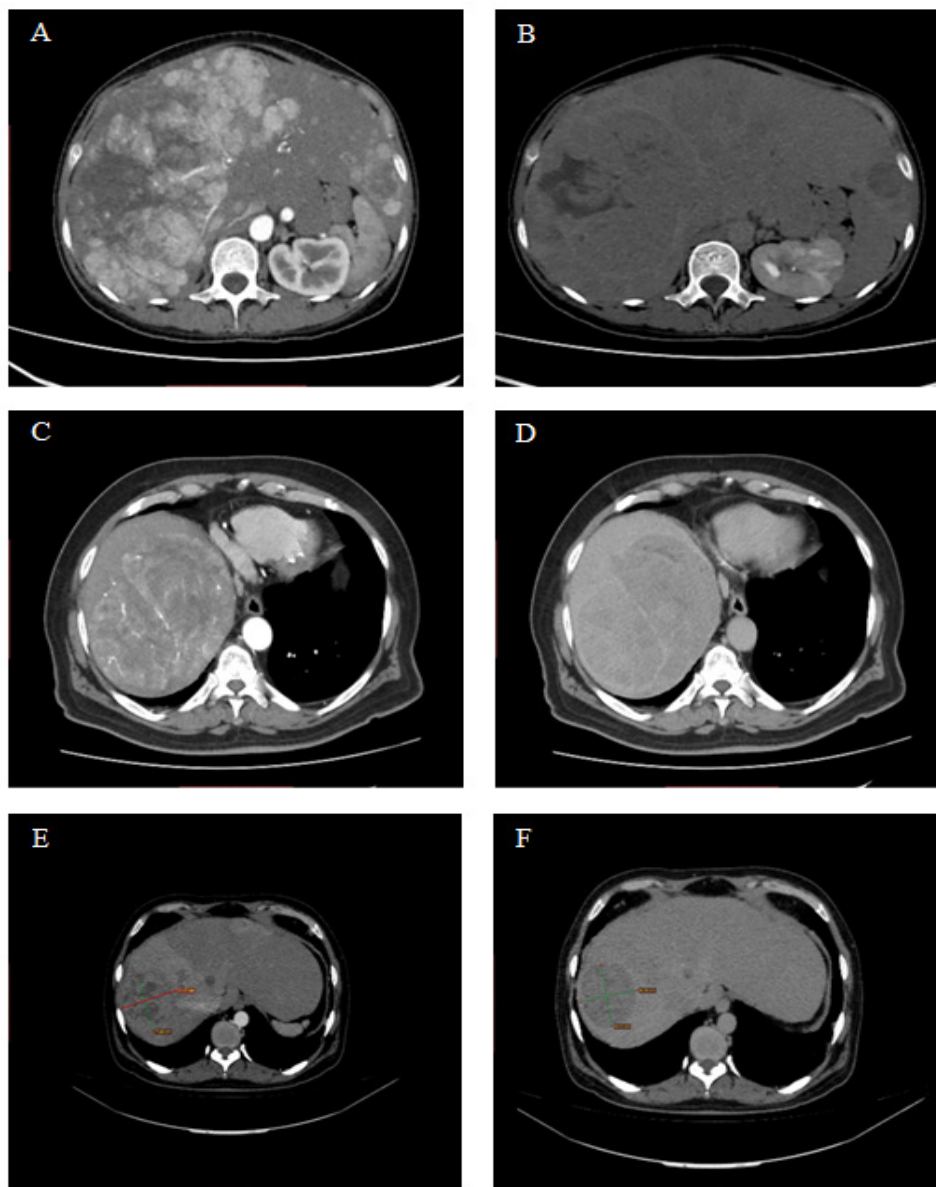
CT Images of HCC Patients. (A-B) Innumerable round circumscribed nodular enhancing lesions throughout the hepatic parenchyma, particularly in the right hepatic lobe, which are demonstrating arterial enhancement and delayed washout, worrisome for HCC. (C-D) Huge 14 x 11.5 x 8.7 cm size hypervascular avidly enhancing lobulated mass in segment 8 and 7 of the liver. This shows washout on the venous and delayed phase images and has a capsule around it suggestive of HCC. (E-F) Large angio invasive HCC in segment 8/7 of the liver with infiltrates disease in segment 5 and 8 of the liver.
